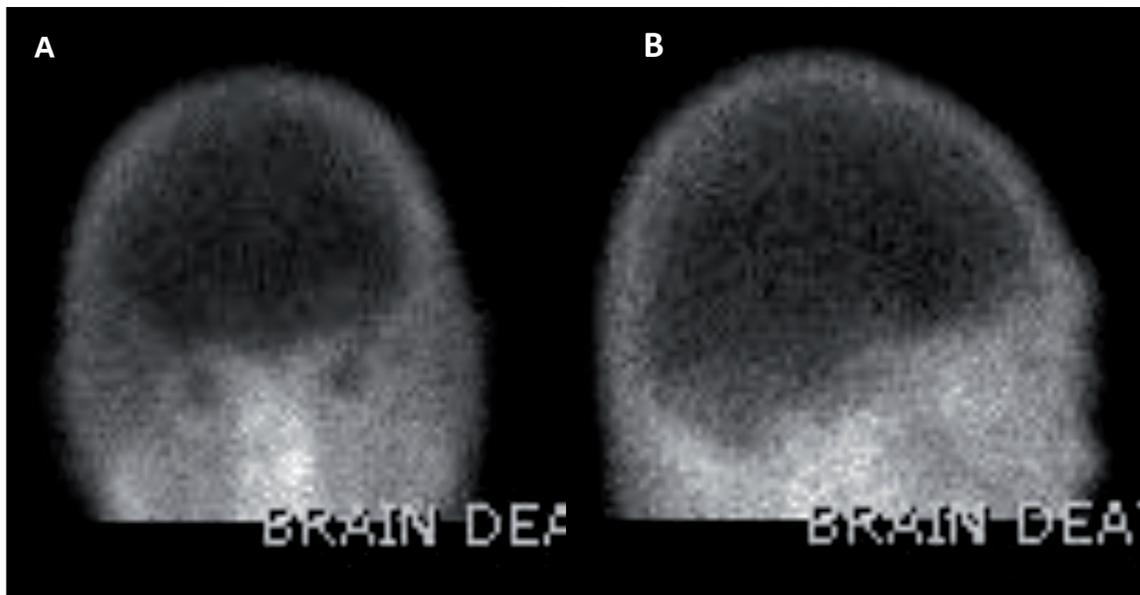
“Hallow skull”/“empty bulb” sign shown in brain death patient using (A) AP and (B) lateral nuclear scintigraphy imaging. Flow and delayed imaging demonstrated no significant intracranial flow or parenchymal uptake.
